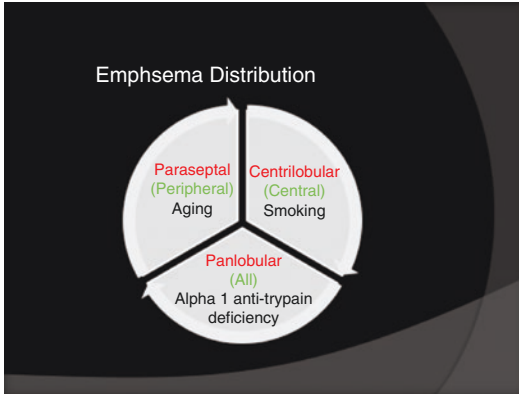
Distribution of emphysema on CT
